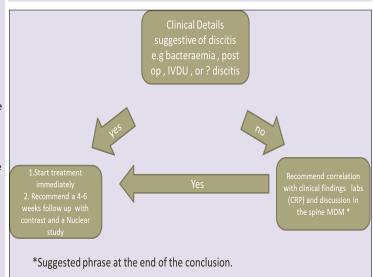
Recommended pathway for MRI equivocal discitis
